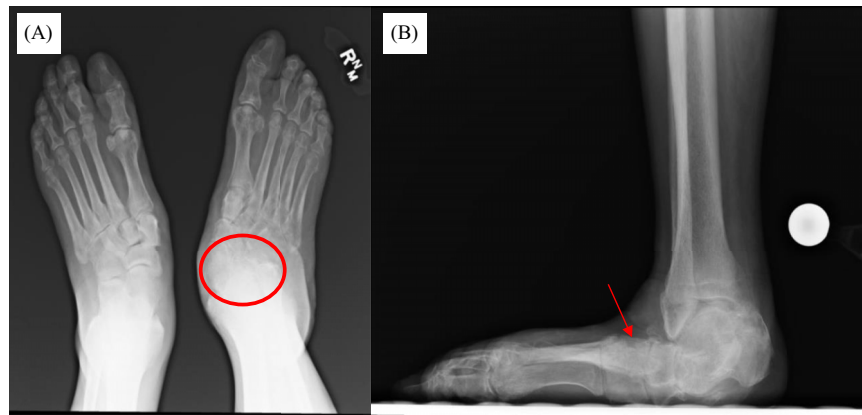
Weight-bearing radiographs: (A) Bilateral anterior-posterior. (B) Lateral radiographs 1.5 years after the patient’s initial presentation to the emergency department. There is evidence of degenerative changes at the talonavicular joint (A – red circle) in addition to midfoot collapse (B – red arrow).
